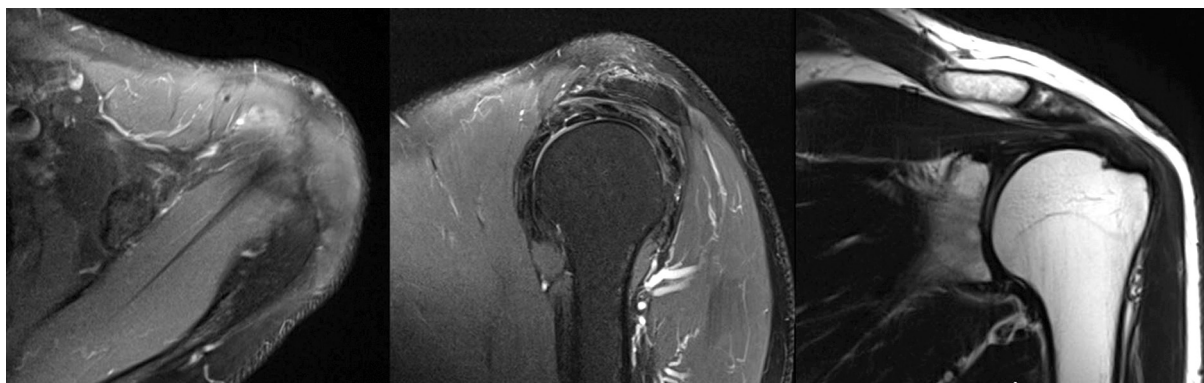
MRI of the left shoulder of patient I. at two years of surgery. Sections in the coronal, axial and sagittal planes
